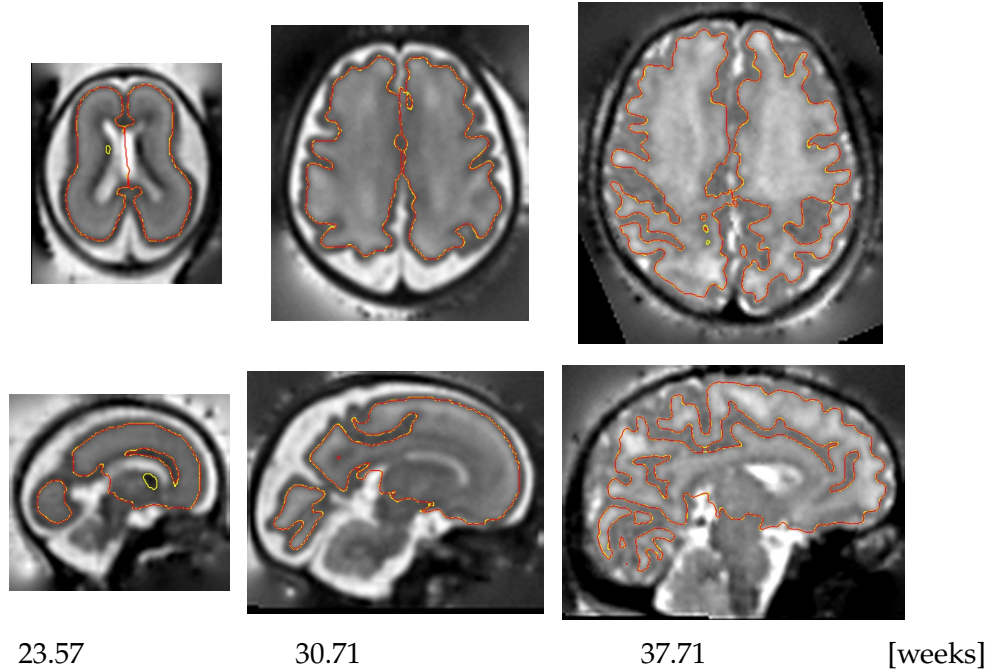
Cortical Surface Extraction. Cortical surface models for a selection of gestational ages are overlaid on their corresponding MR image volumes. The isosurface of the sub-cortical tissue probabilities is shown as a yellow contour while the cross-section of the cortical surface model is overlaid as a red contour.
